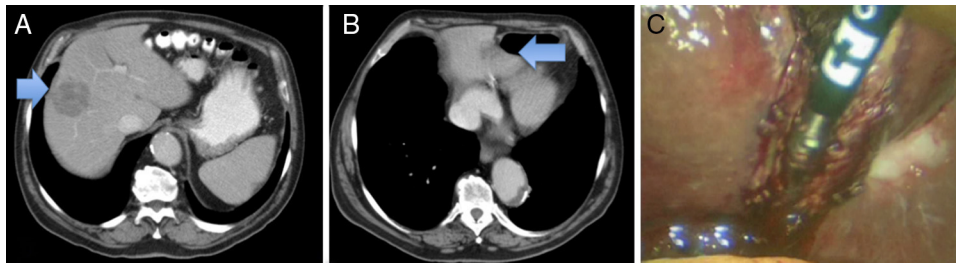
CT scan: (A) metastasis of the right liver; (B) metastasis of the left lateral section; (C) laparoscopic resection.
